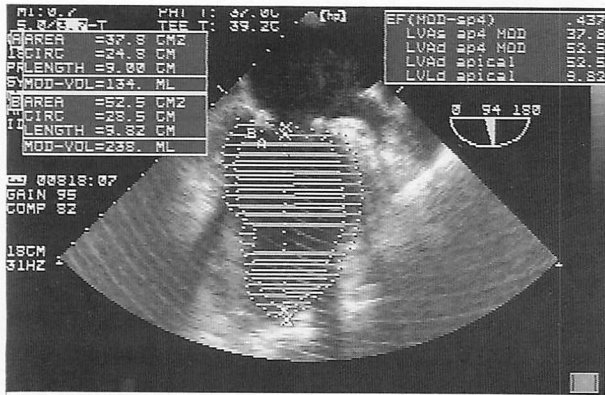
Postoperative echocardiogram (3 days after surgery)
